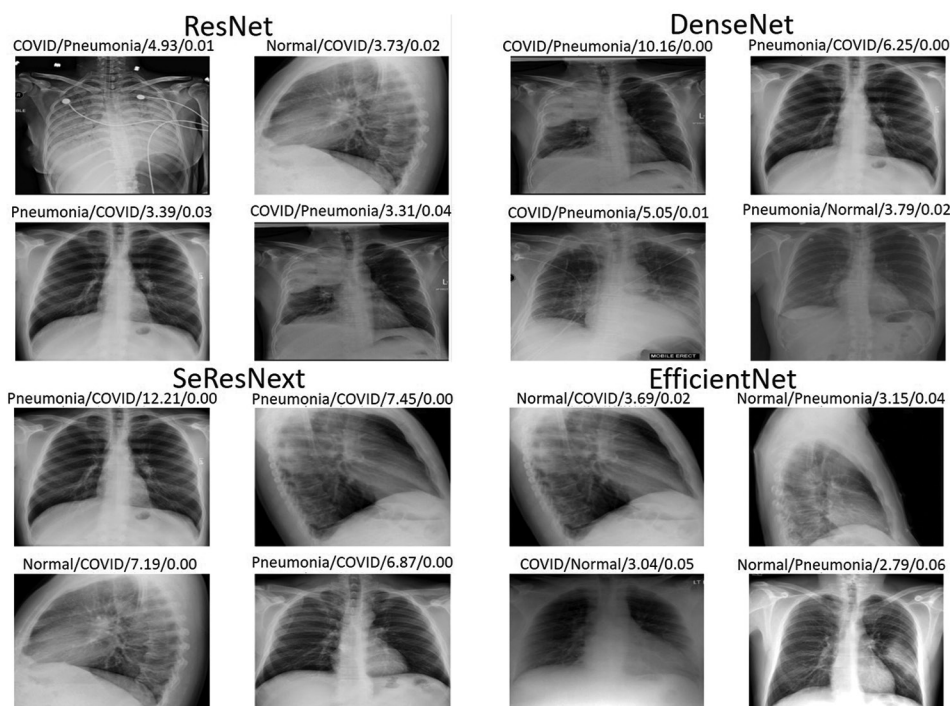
Misclassified X-ray images with prediction details using ResNet, DenseNet, SeResNext, and EfficientNet models. On the top of each subplot, “Prediction/Actual/Loss/Probability” details for each individual image are shown.
